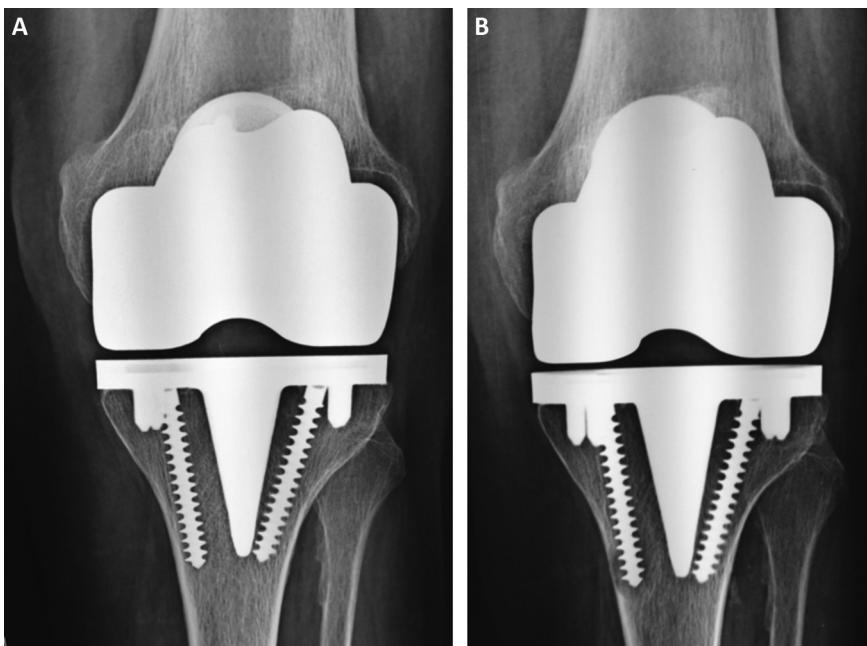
Normal radiographic appearance after 7 years (A) and appearance of osteolysis along screw after 10 years (B).
